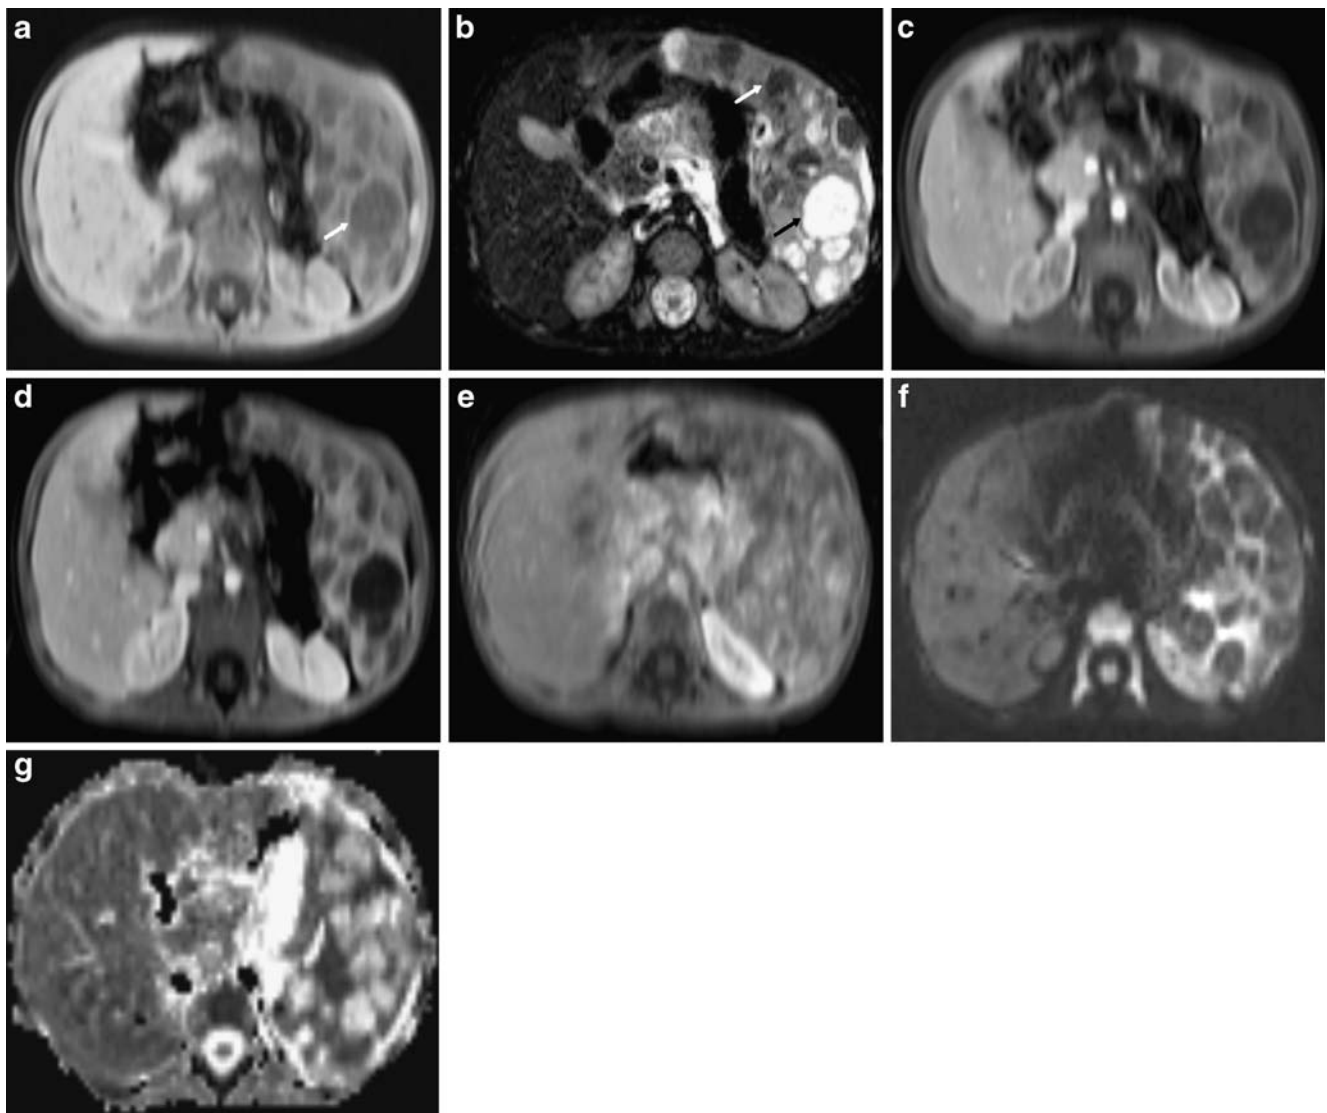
MRI. a Axial T1-W image demonstrates well-demarcated hypointense lesions (*arrow*). b The lesions are predominantly hyperintense (*black arrow*) on axial T2-W images. Few of these lesions are hypointense (*white arrow*) because of hemosiderin deposition. c–e These lesions show mild progressive contrast
